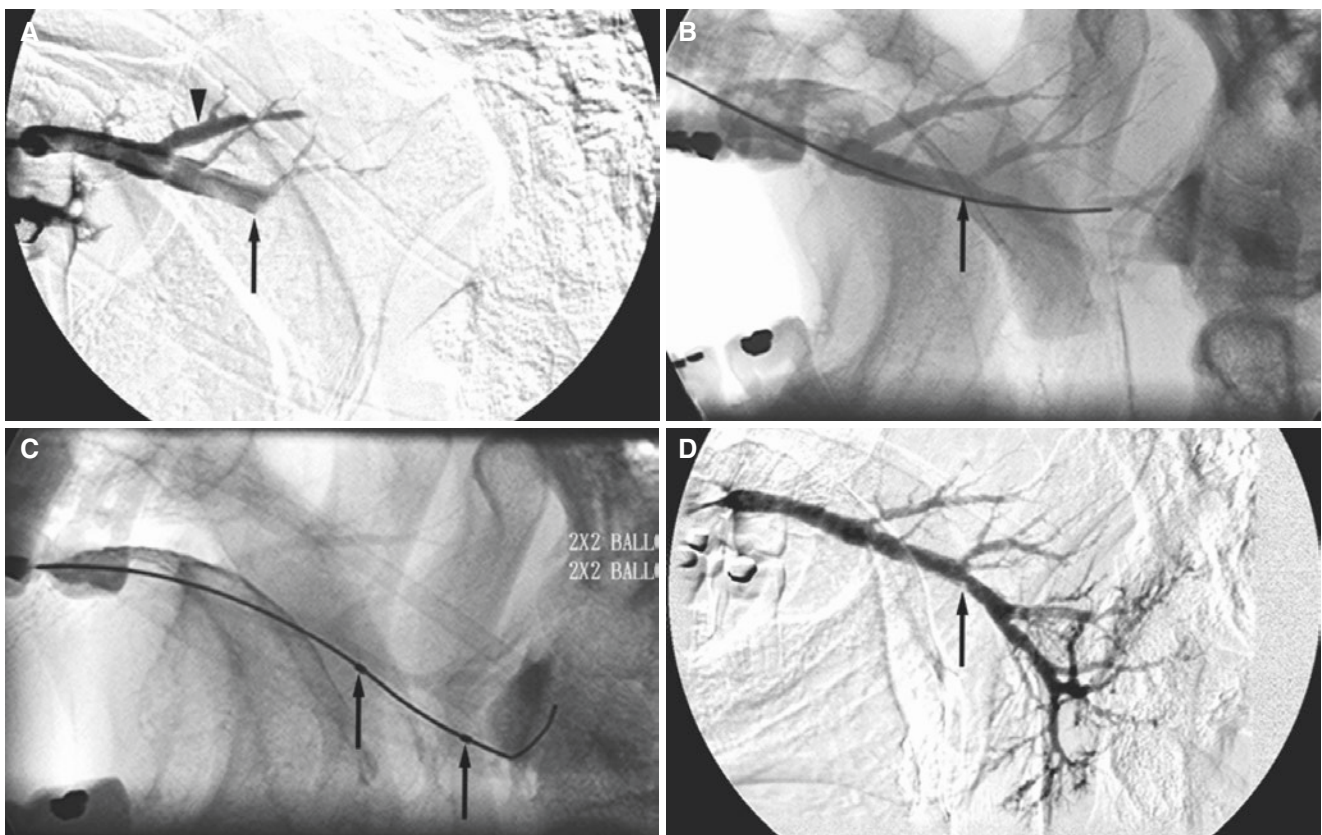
Parotid sialography; abnormal filling of Stensen's duct and no filling of parenchyma before successful duct ballooning. (A) Digital subtraction sialography shows abrupt blockage of mid Stensen's duct (*arrow*) and filling of secondary ducts (*arrowhead*) and third ducts more enhanced than usual. (B) Plain film sialography (fluoroscopy) after probing with a guide wire (*arrow*) shows that blockage could be
